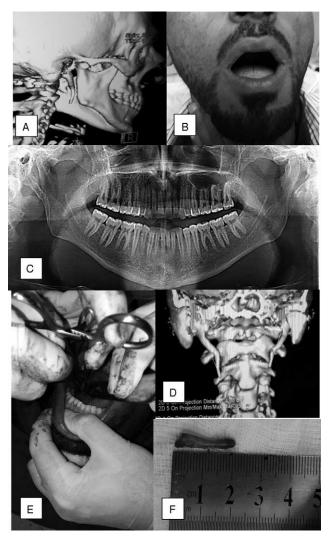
(A) Lateral view three-dimensional (3D) of computed tomography (CT) scan showing elongated styloid process. (B) Patient front view showing limited mouth opening. (C) Panoramic radiograph (OPG) showing elongated styloid process. (D) Posterior view 3D of CT scan showing elongated styloid process. (E) Intraoperative view of showing resection of elongated styloid process. (F) Resection of 2.2 cm from styloid process.
